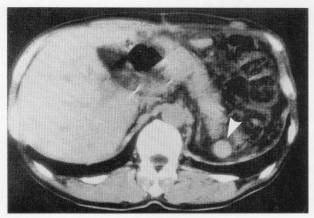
CT image at the level of the pancreas. An abnormal small nodule (arrowhead) in the left posterior abdominal cavity is seen.
